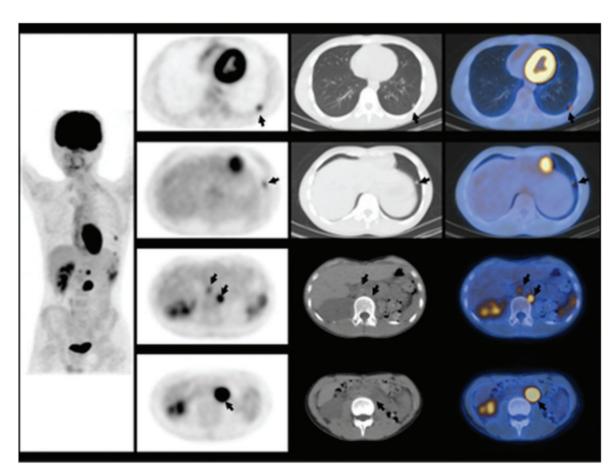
With the use of PET/CT imaging, hypermetabolic PCC lesions were observed in five locations (shown by arrows): three locations in the bilateral para-aortic region and two locations in the left lower lung. Upper two rows: Two hypermetabolic PCC lesions in the left lower lung. Lower two rows: Three hypermetabolic PCC lesions in the bilateral para-aortic region. Left: Maximum intensity projection image (MIP) in FDG (18F-FDG or fluorodeoxyglucose) PET (Positron emission tomography). Left column: Axial views of FDG PET. Middle column: Axial views of CT. Right column: Axial views of FDG PET/CT (18F-FDG PET/CT) fusion images.
